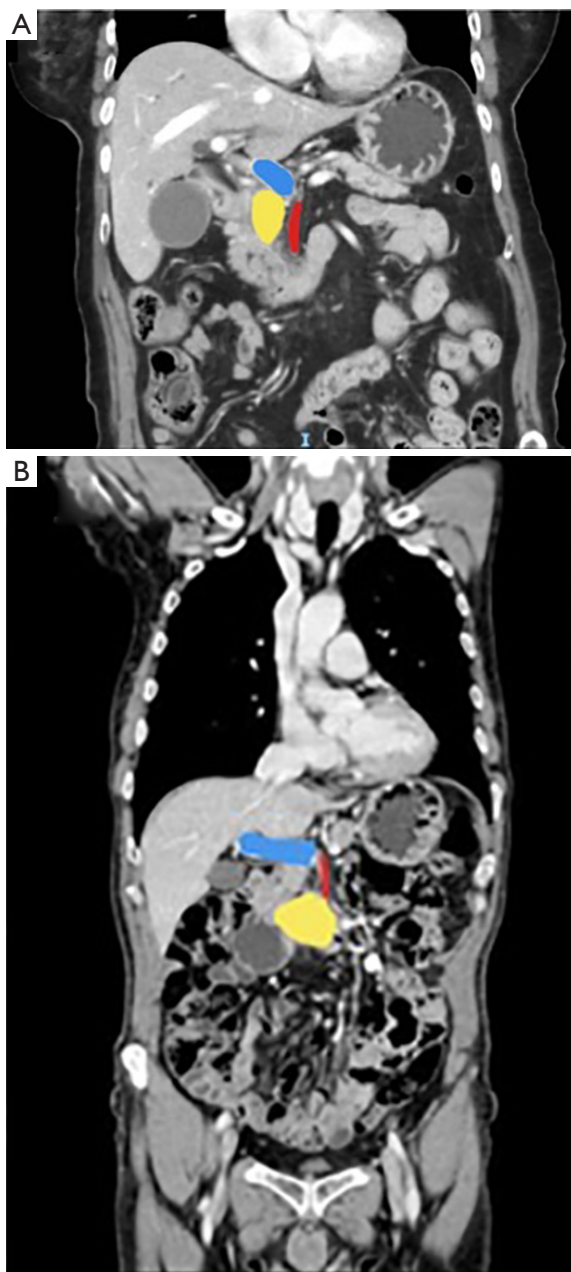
Pre-operative abdominal CT scan. (A) CT scan of a small uncinate process; (B) CT scan of a large uncinate process. In yellow the uncinate process; in blue the portal vein; in red the superior mesenteric artery. CT, computed tomography.
